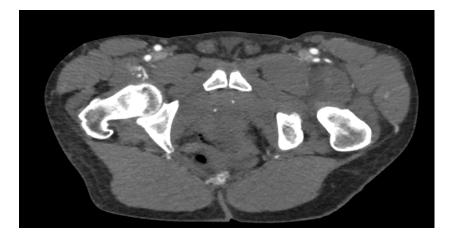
CT pelvis pre (top image) and post IV contrast (bottom image): Calcification in the iliopsoas without contrast enhancement.
